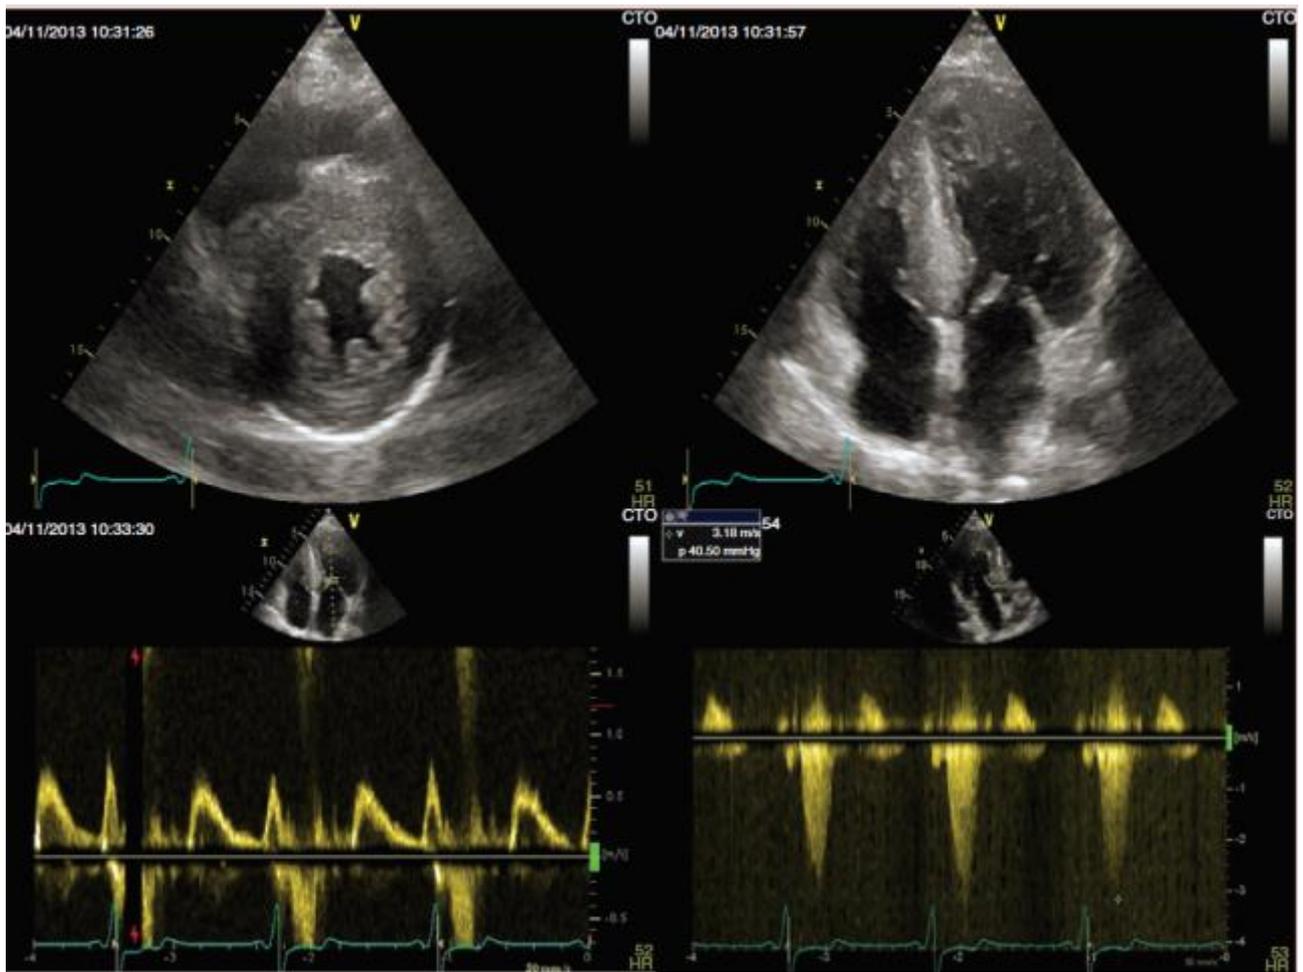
Echocardiography documented severe concentric and symmetric left ventricular hypertrophy with left ventricular tract obstruction of 40 mmHg at rest and abnormal ventricular relaxation.
